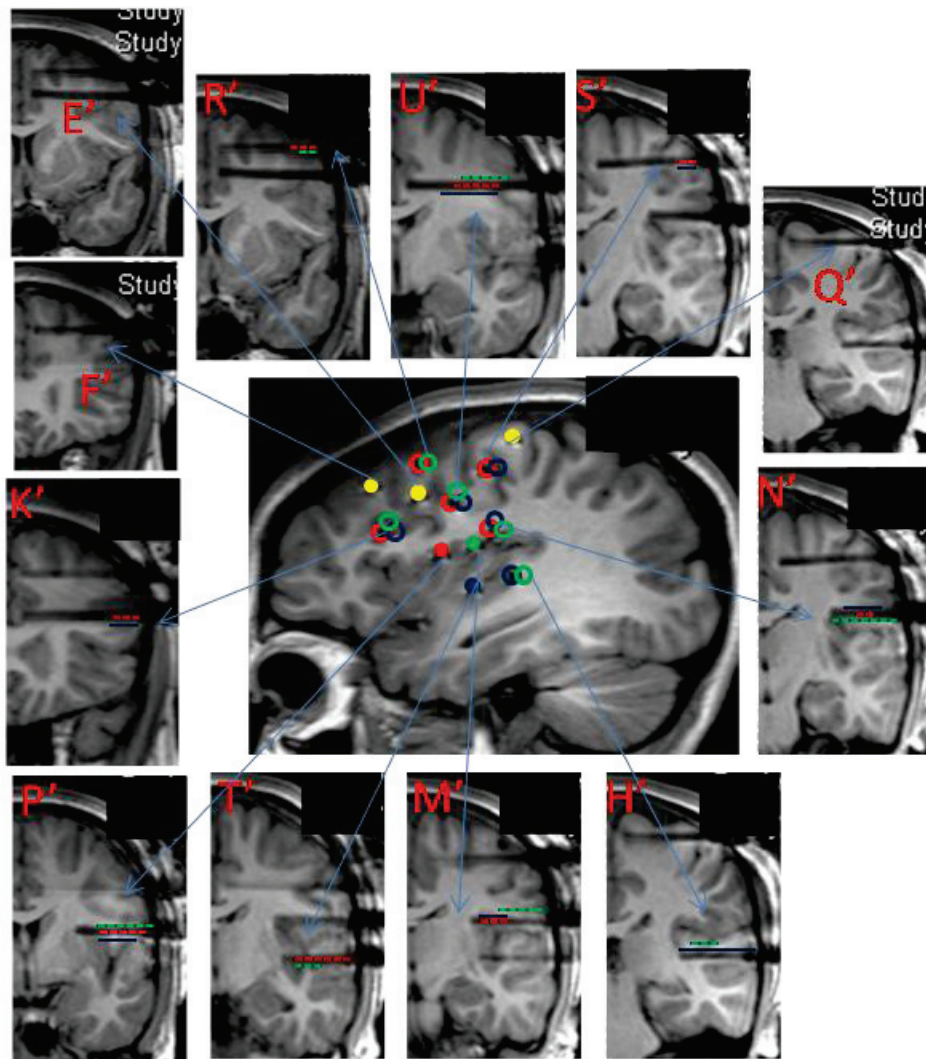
10: Patient 10 MRI with electrodes in place (right hemisphere). Central sagittal image: each insular electrode is represented by a unique colored solid circle; non-insular electrodes are represented by empty circles with the color of each of the insular electrode they are responding to. Yellow solid circles are for non responding electrodes. Peripheral coronal images: a cross-section of each electrode with its name and its responding contacts (responses are indicated by color coded dotted lines, representing the color of the corresponding stimulated insular electrode).
